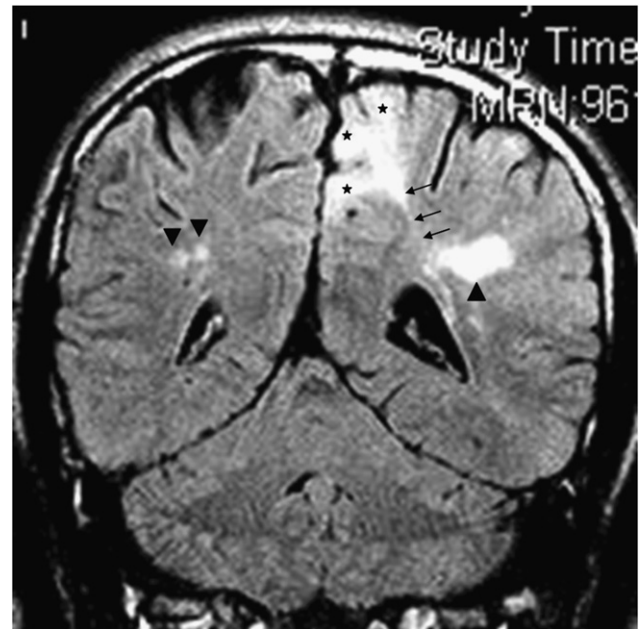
FLAIR MRI of lesion load score in TSC patients: each cortical tuber (★) on the separate gyrus was scored as 1, each transmantal white matter lesion (←) was scored as 1, each nodular white matter lesion (▼) was scored as 1, and each wedge-shaped white matter lesion (▲) was scored as 2.
